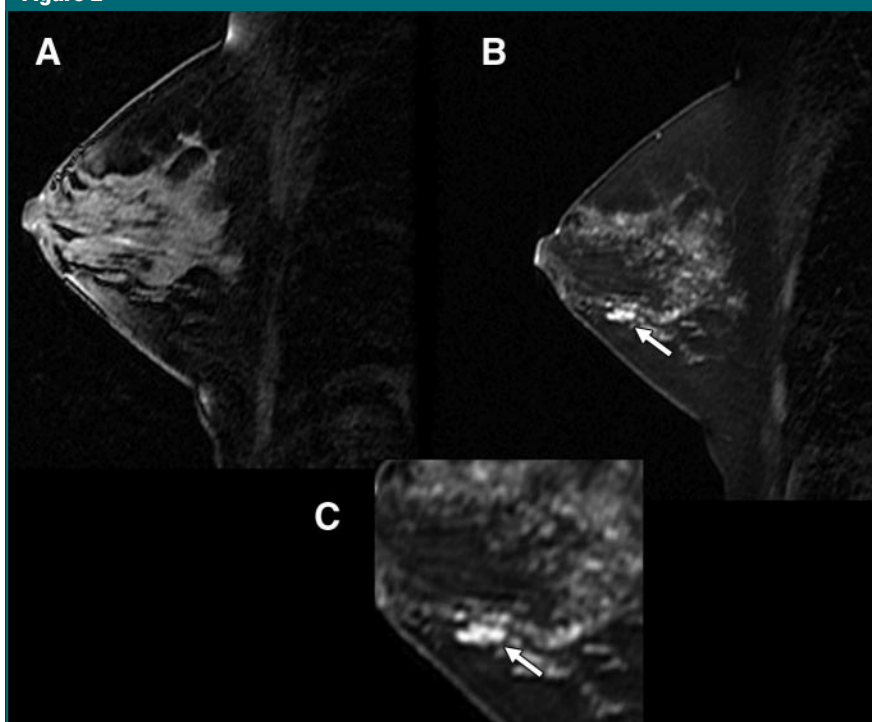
Negative screening mammogram and US of 46-year-old woman. Sagittal precontrast (A, T2-weighted fast spin-echo with fat suppression) and postcontrast (B, T1-weighted gradient-echo with fat suppression) images demonstrate $8 \times 3 \times 3$ linear focus of enhancement in left breast (C)(arrow). Pathologic report proved infiltrating ductal carcinoma.
